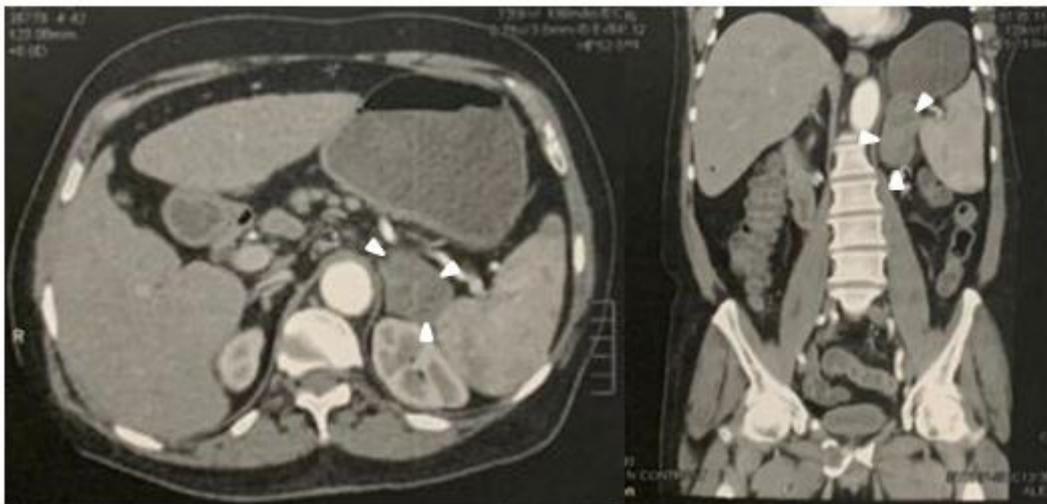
Enhanced PelviAbdominal CT shows left adrenal mass (white arrow heads) in axial and coronal images
